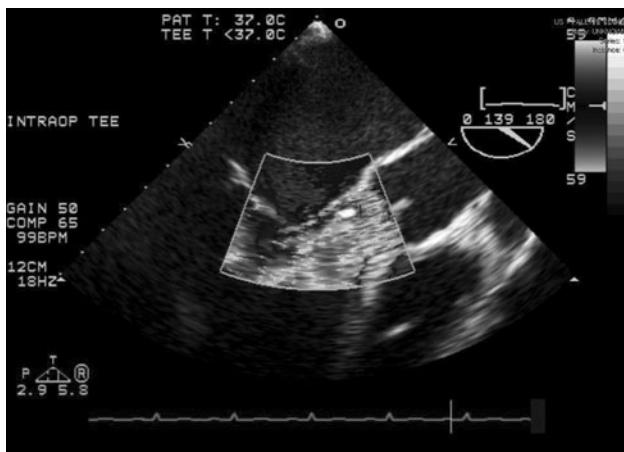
Color flow Doppler demonstrates severe aortic regurgitation
